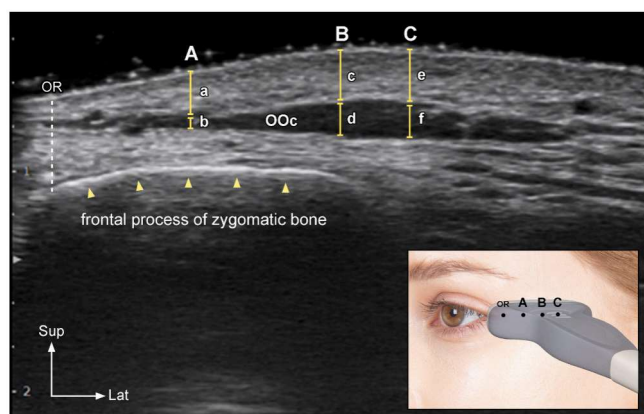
Ultrasonographic analysis of the orbicularis oculi muscle (B mode, transverse view, 16-MHz linear transducer). Each parameter was measured at three landmarks. (A) the depth of the orbicularis oculi muscle from the skin surface at point A; (B) the thickness of the orbicularis oculi muscle at point A; (C) the depth of the orbicularis oculi muscle at point B; (D) the thickness of the orbicularis oculi muscle at point B; (E) the depth of the orbicularis oculi muscle at point C; (F) the thickness of the orbicularis oculi muscle at point C
